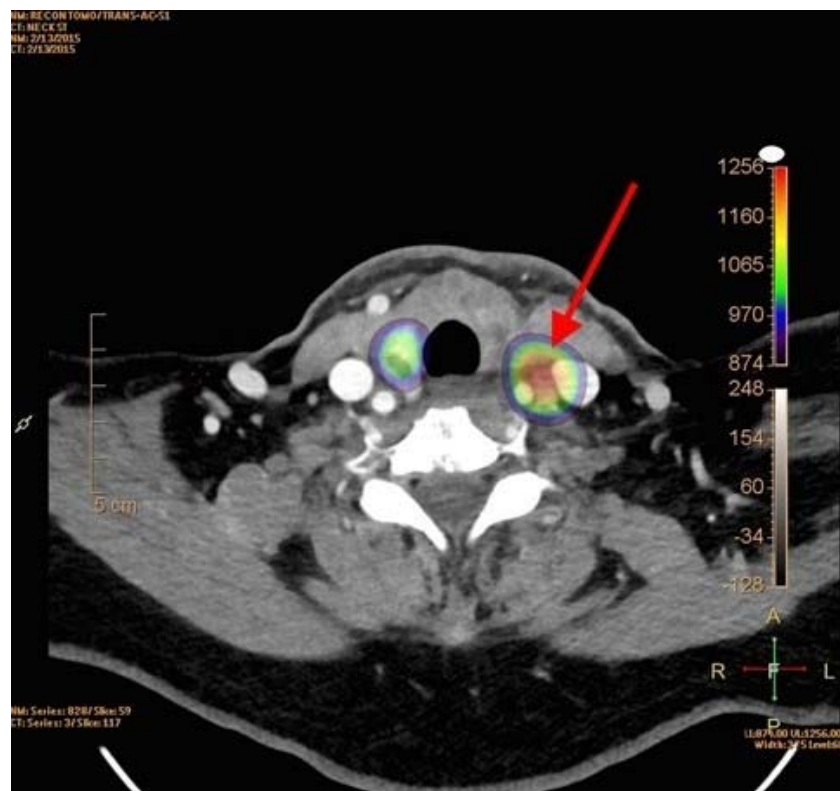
Fused SPECT/high-res CT localizes uptake to a soft tissue lesion in the left carotid sheath.
